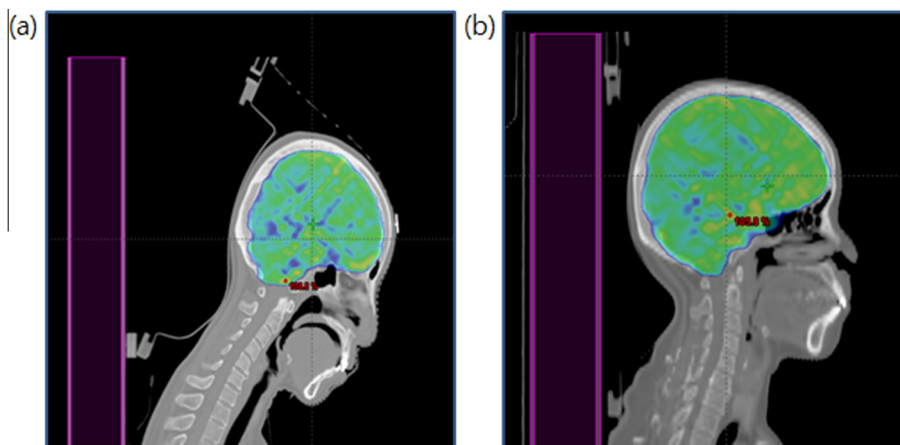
A CT image from a randomly selected patient. (a) is an image of the patient when a wedge was placed under the head to effect tilting; (b) is an image of a patient receiving treatment in a standard supine position.
